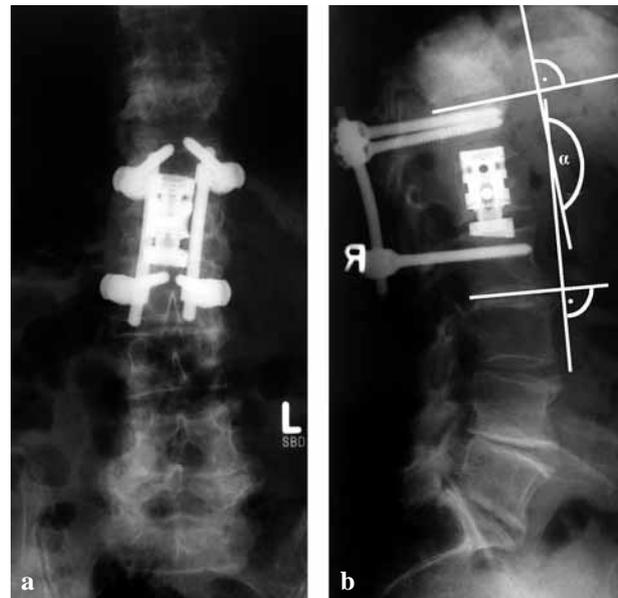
Postoperative x-rays of the same patient 18 months postoperatively: The loss of correction is shown by the increased local kyphosis (α).
